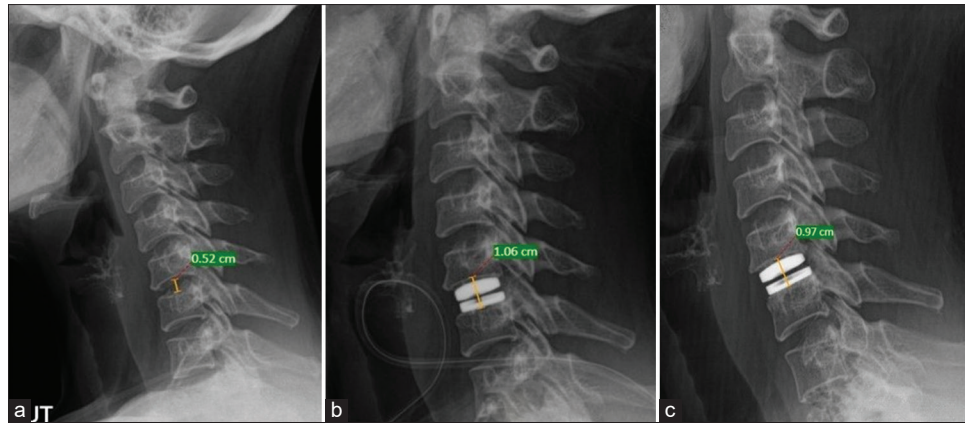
X-ray depicting disc height preoperatively-0.52 cm (a), immediate postoperatively-1.06 cm (b), 3 months postoperatively – 0.97 cm (c) in a patient with total disc replacement
